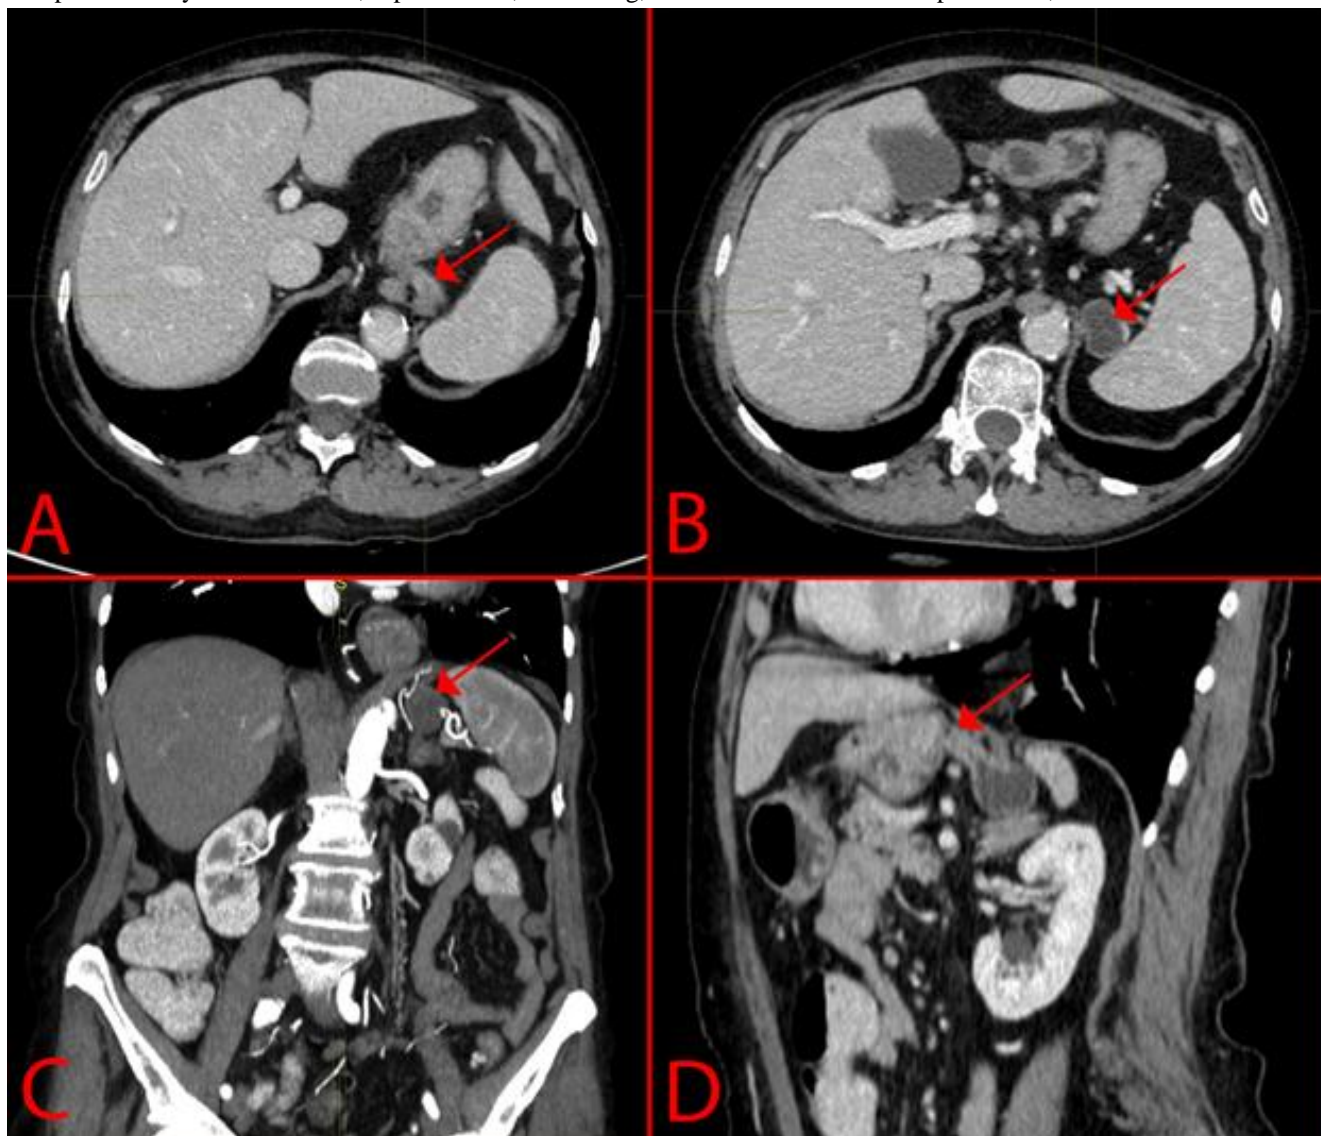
CT image of the abdomen. A: Axial section, venous phase (arrow indicates the neck of the diverticulum); B: Axial section, venous phase (arrow indicates the fundus of the diverticulum); C: Frontal section (arterial phase) demonstrating the fundus of the diverticulum located in a highly vascularized zone; D: Sagittal section, venous phase (arrow indicates the neck of the diverticulum).
